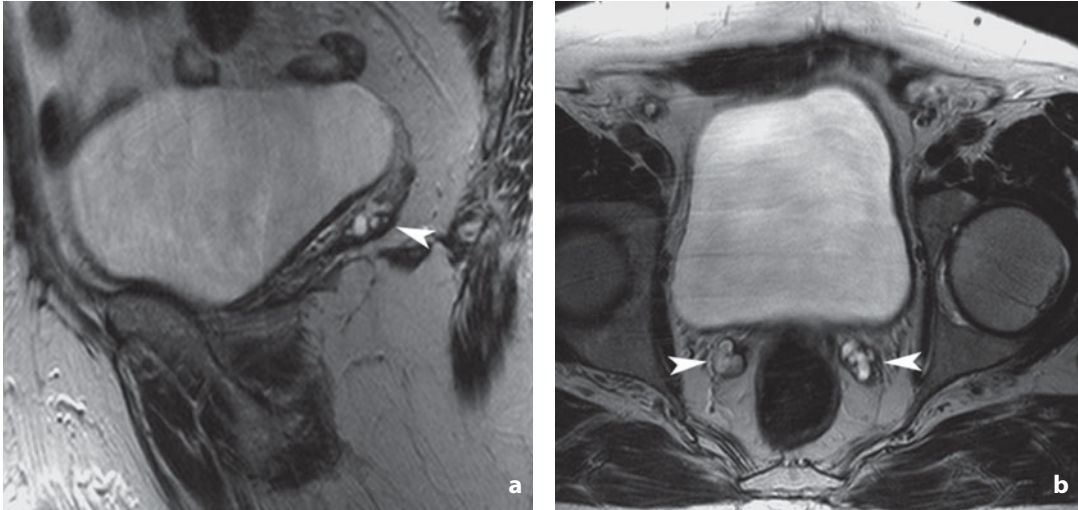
Magnetic resonance. Sagittal (a) and axial (b) T2-weighted images. Residues of the seminal vesicles (arrowheads) after radical prostatectomy
